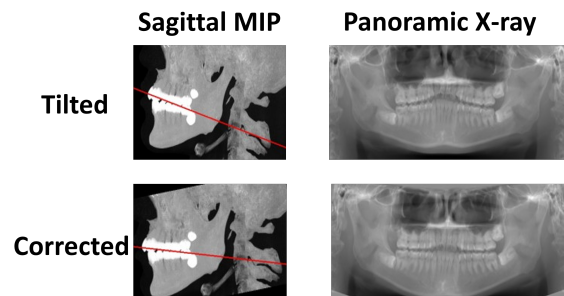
Result of tilt correction relative to the axial plane for an upward-facing CT scan.
